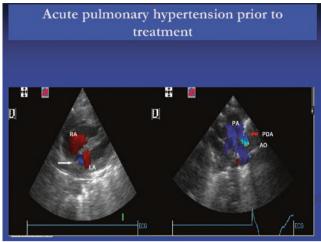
Echocardiography showing severe pulmonary hypertension with a right-to-left shunt through the foramen ovale (white arrow) and the ductus arteriosus (red arrow), prior to treatment
